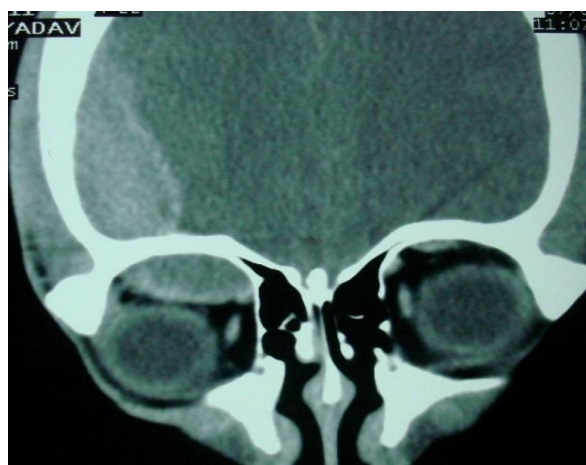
CT scan brain & orbit (coronal section) showing left frontal EDH and orbital subperiosteal hematoma causing downward displacement of the globe.
